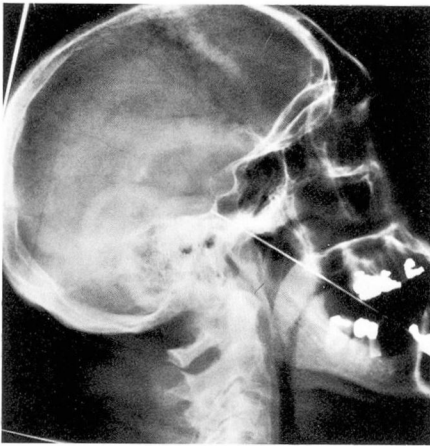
Lateral roentgenogram of the electrode position.
